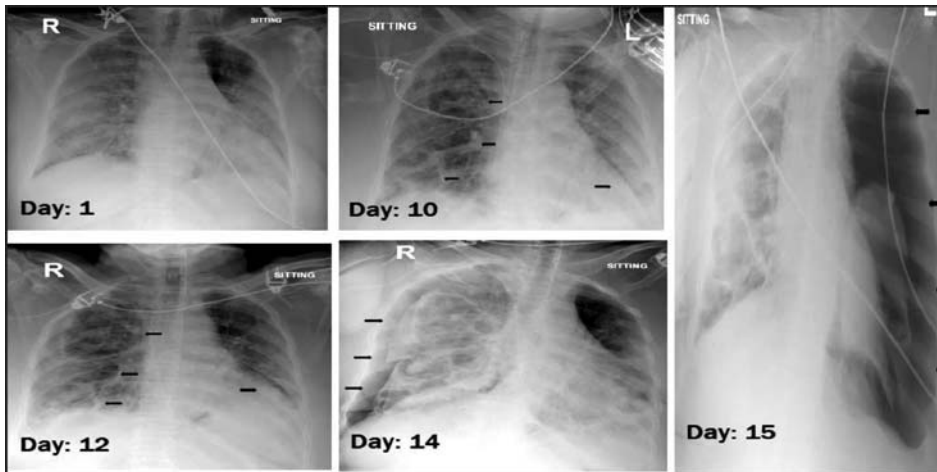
Initial chest X-ray of the patient on admission is shown as on Day 1; multiple cavitary lesion can be seen more on the right side on day 10, 12 and 14; left sided pneumothorax can be visualised in chest x-ray of day 15.
